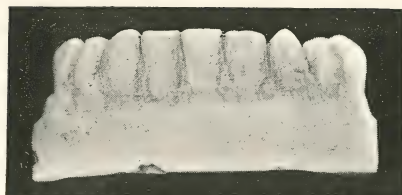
At the left is a model of the lower teeth of an adult in which one incisor is missing, and on the right is the radiograph showing its absence from the alveolus.
